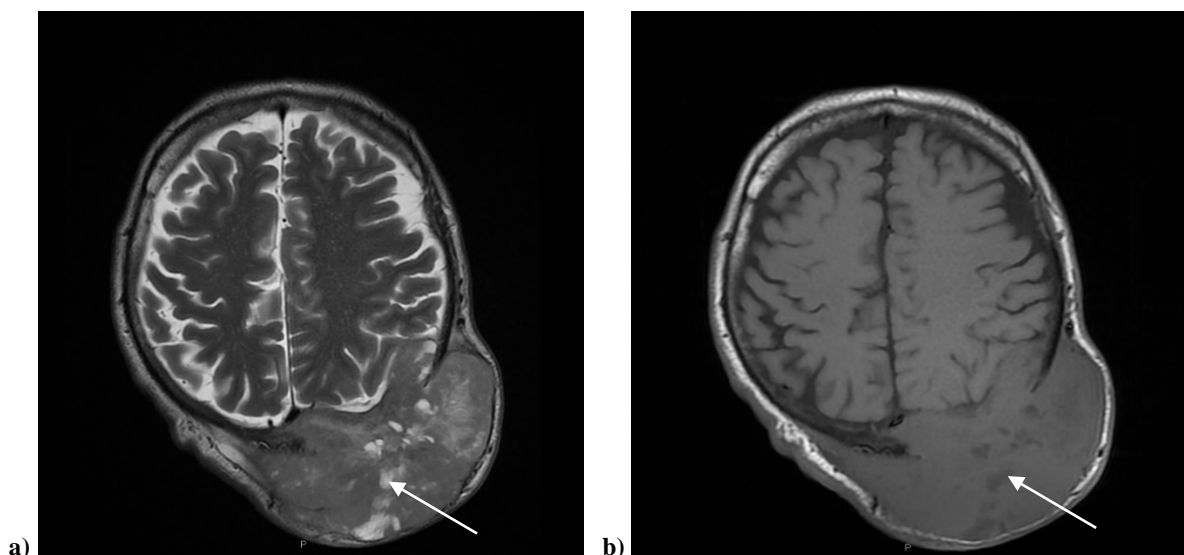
Magnetic resonance imaging of the brain. a) Transversal T2W image; b) Transversal T1W image. Large inhomogeneous tumor in the left parietooccipital region with intracranial extension. The lesion is predominantly T2W/T1W isointense with zones of T2W hyper/T1W hypointensity (indicated by arrow). T2W – T2 weighted; T1W – T1 weighted.
